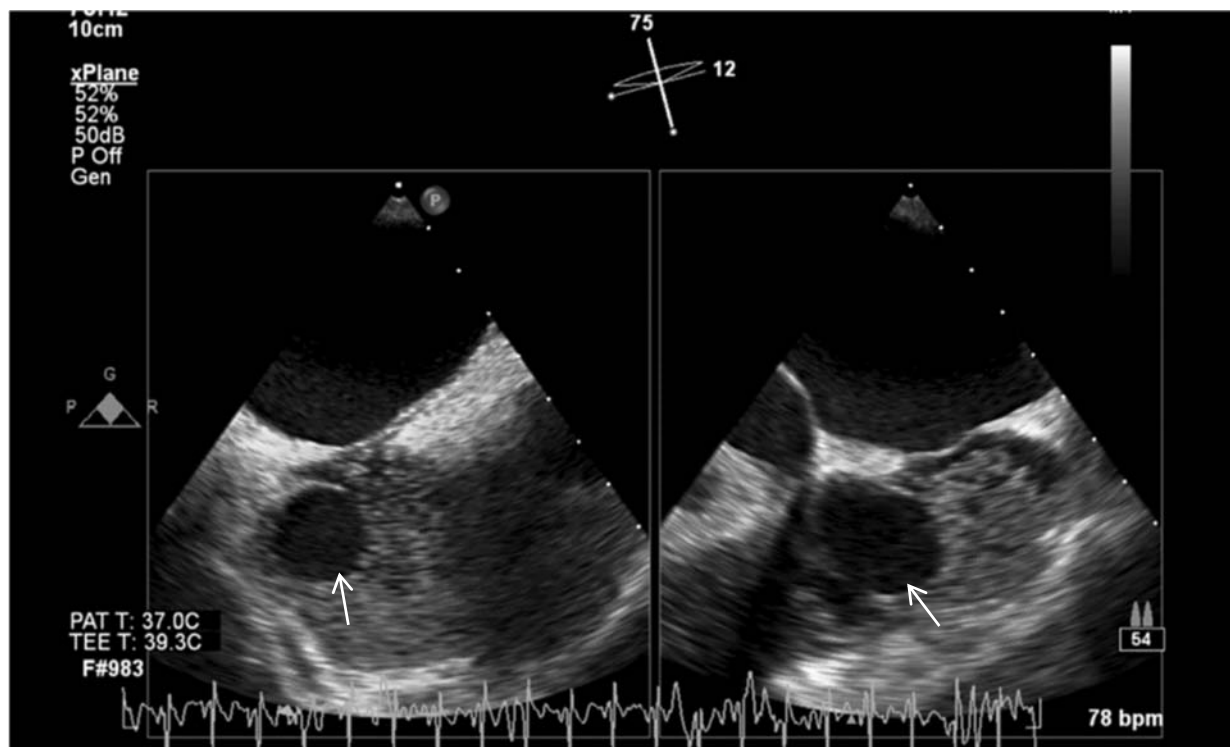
Contrast transesophageal echocardiography images in midesophageal modified bicaval view. The use of contrast highlights the oval-shaped cystic mass in the right atrium attached between the tricuspid valve annulus and the orifice of the inferior vena cava. The mass does not show contrast uptake
